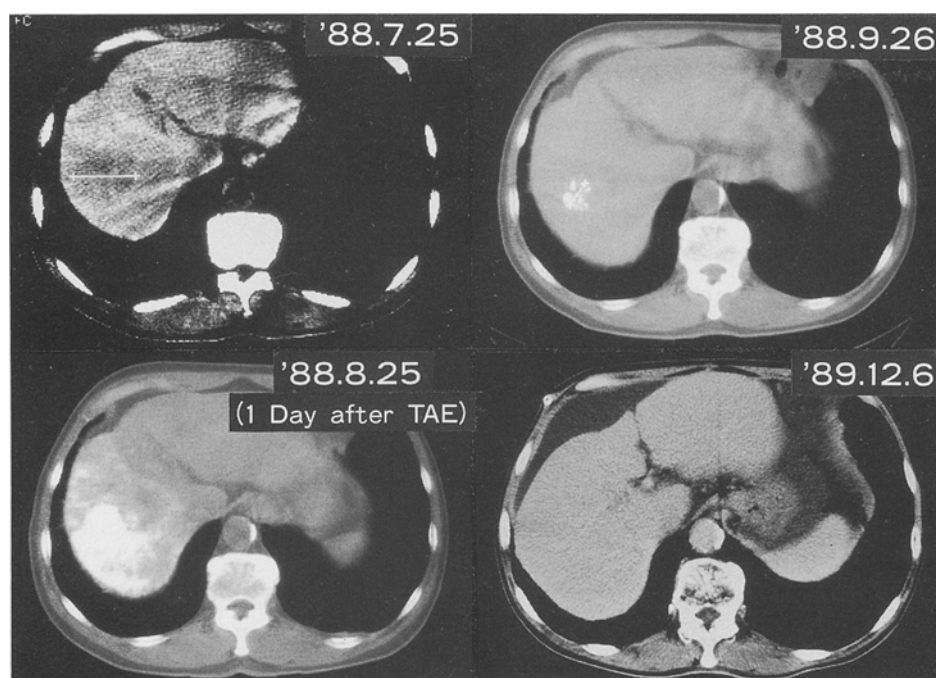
Computed tomography in a 71-year-old man (case 4). A low-density area was detected in the right hepatic lobe. About 1 month after TAE, the patient showed a PR. During laparotomy on Oct. 6, EIT was performed. About 3 months after TAE, the patient achieved a CR
